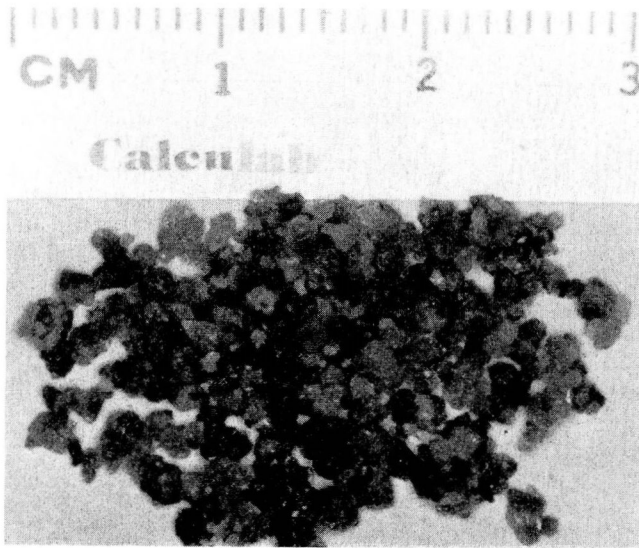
Calculus, following ultrasonic fragmentation and extraction.
